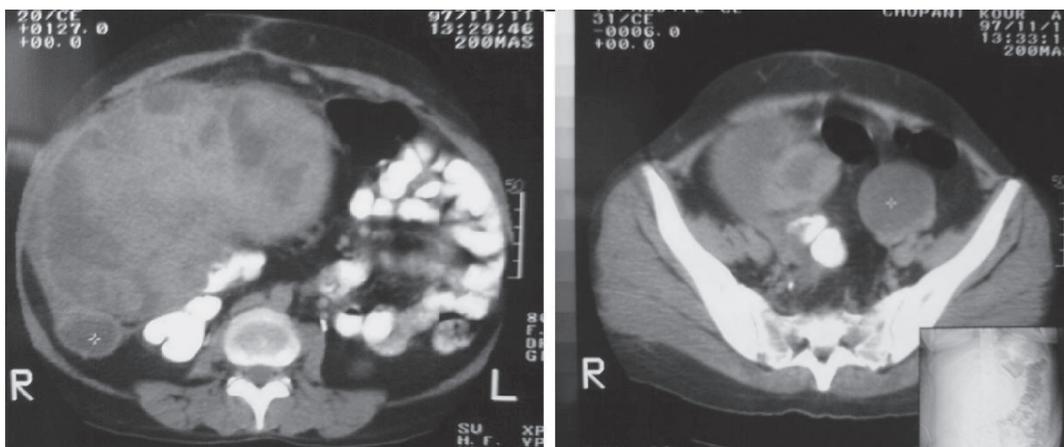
Abdominopelvic Computed Tomography shows a large mass in the right side of abdominal cavity.
